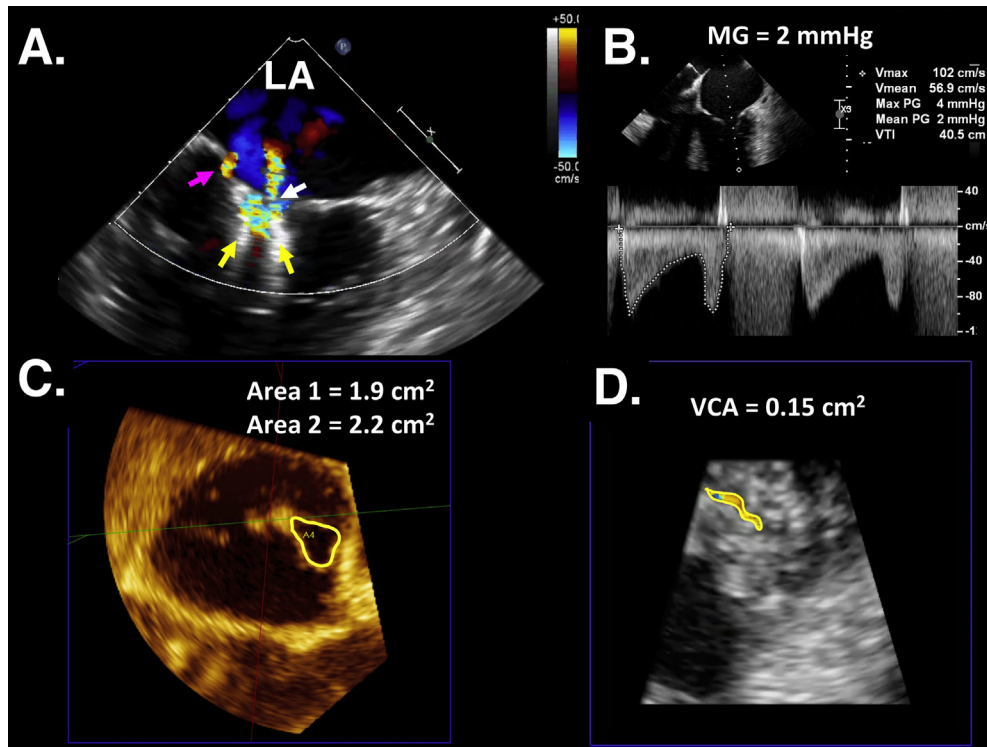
(A) 2D TEE color flow Doppler of commissural view postdeployment of two clips (*yellow arrows*) showing a trivial medial jet (*magenta arrow*) and a mild jet (*white arrow*) between the two clips. (B) Mean transvalvular gradients can be measured in either orifice, and gradients > 5 mm Hg may result in suboptimal clinical outcomes. (C) Using multiplanar reformatted, planimetry of each residual orifice will allow for calculation of cumulative MVA. Each orifice should be measured in separate planes as they are not in the same plane. (D) Planimetry of the SAX of the residual regurgitant jet will allow for measurement of VC area (VCA). MG, Mean gradient.
